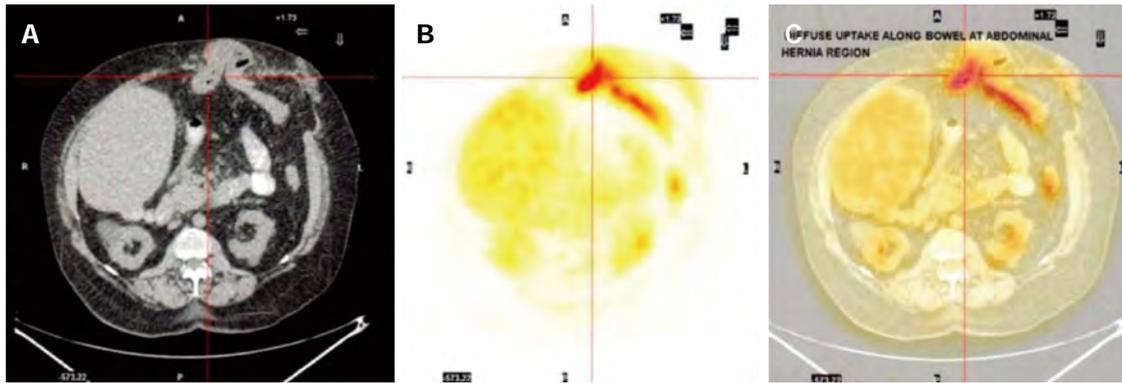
Computed tomography scan (A), fludeoxyglucose positron emission tomography (B) and combined computed tomography positron emission tomography image (C) across the site of incisional hernia. A: Incarcerated hernia with a loop of bowel; B: Confirms "hot spot" with increased fludeoxyglucose uptake which corresponds with the centre of the incarcerated bowel loop within the hernia with some activity along the efferent loop distal to the hernia.
